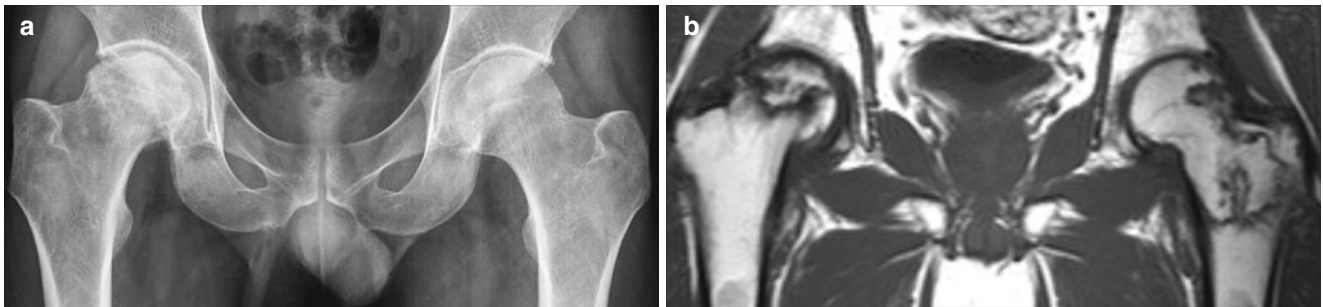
Early stage of ON in a 36-year-old male patient. (a) The right femoral head shows ON with subchondral collapse, and marginal sclerosis along the lesion is seen. The left femoral head shows suspicious sclerosis. (b) T1-weighted coronal image shows ON of both femoral heads. ON of the left femur shows involvement of the head and intertrochanteric portion
